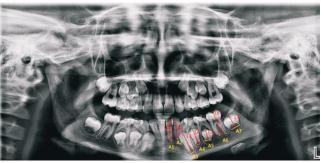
An example of analysis by Cameriere's method. The upper radiograph shows values obtained by Image J Software; the lower radiograph shows corresponding labels in the formula. ('A' represents the width of the open apex; 'L' represents the vertical length of the tooth)
